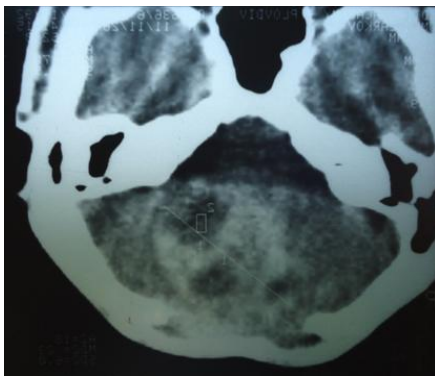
CT image of hemangioblastoma
